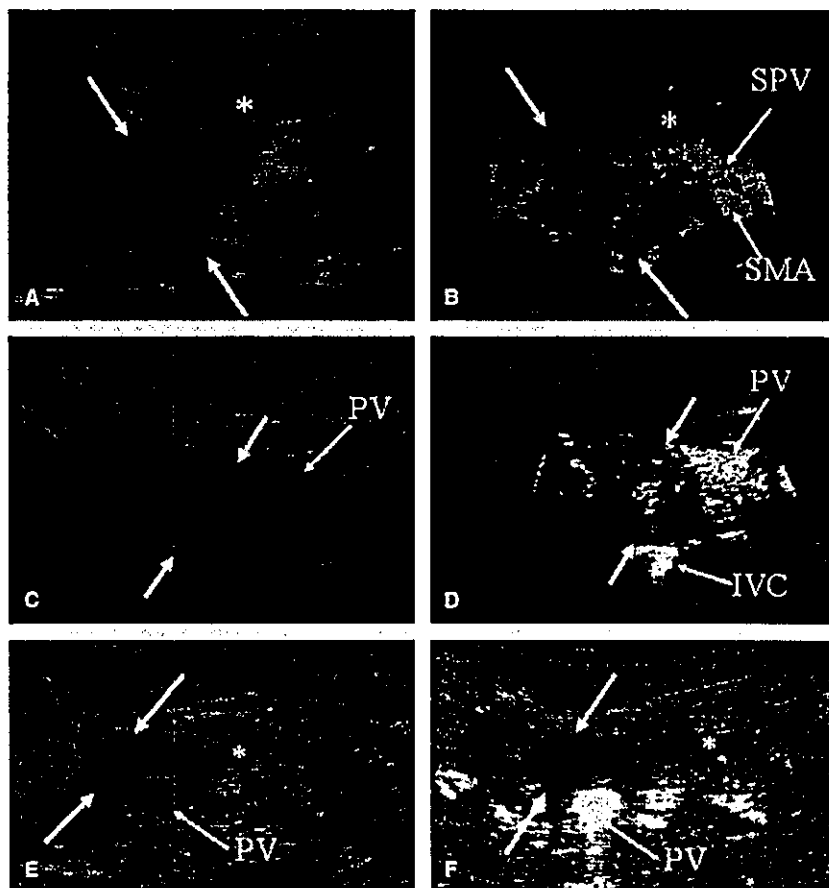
Type classification by intensity of intratumoral vascular signal. A: The ultrasonographic image before injection of the contrast medium. Well-differentiated ductal adenocarcinoma (bold arrow) measuring 4 cm in the head is shown. B: The image captured by dynamic flow 40 seconds after administration of the contrast medium. A strong vascular signal is observed in the tumor (bold arrow). This case is classified as type A. C: The ultrasonographic image before injection of the contrast medium. Poorly differentiated ductal adenocarcinoma (bold arrow) measuring 3 cm in the head is shown. D: The image captured by dynamic flow 35 seconds after administration of the contrast medium. Spotted vascular signals are observed in the intratumoral blood flow (bold arrow). This case is classified as type A. E: The ultrasonographic image before injection of the contrast medium. Moderately differentiated ductal adenocarcinoma (bold arrow) measuring 2 cm in the head is shown. F: The image captured by dynamic flow 40 seconds after administration of the contrast medium. Hardly any vascular signal is noted in the tumor (bold arrow). This case is classified as type B. PV, portal vein; SPV, splenic vein; SPA, splenic artery.
